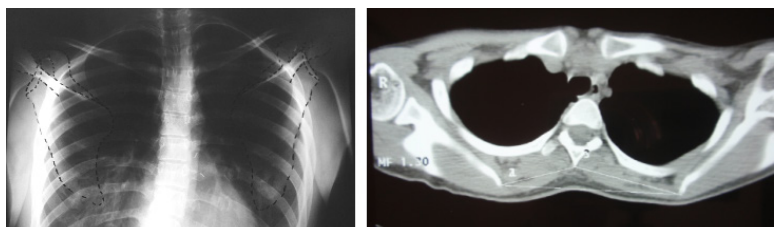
/ A. Final x-ray B. Final CT scan
